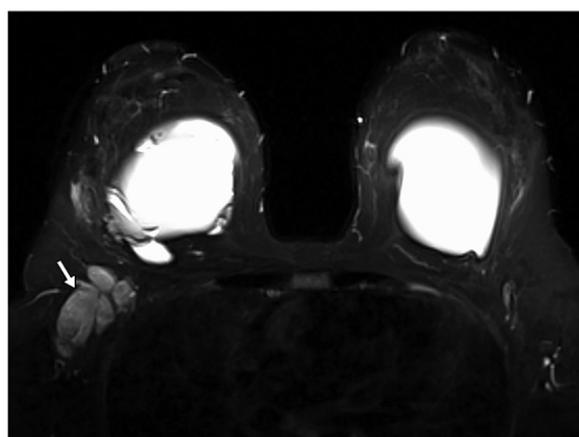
Signs of extracapsular rupture at MR imaging. (a) Sagittal STIR MR image shows a focal contour abnormality and direct discontinuity along the inferior aspect of the silicone implant (arrow), with extrusion of low-signal-intensity silicone into adjacent soft tissues. (b) Axial silicone-selective MR image of the left breast shows free silicone due to extracapsular rupture extruding into the axillary tail region (arrows). (c) Axial silicone-selective MR image of the right breast shows a mass (arrow) along the right parasternal region that exhibited the signal intensity of silicone on images obtained with all sequences (other images not shown), a finding consistent with a benign silicone granuloma. (d) Axial silicone-selective MR image of both breasts demonstrates bulky right silicone-laden lymphadenopathy (arrow) related to rupture of the right implant. The signal intensity of silicone within lymph nodes can be more heterogeneous than that of silicone contained within the implant.
